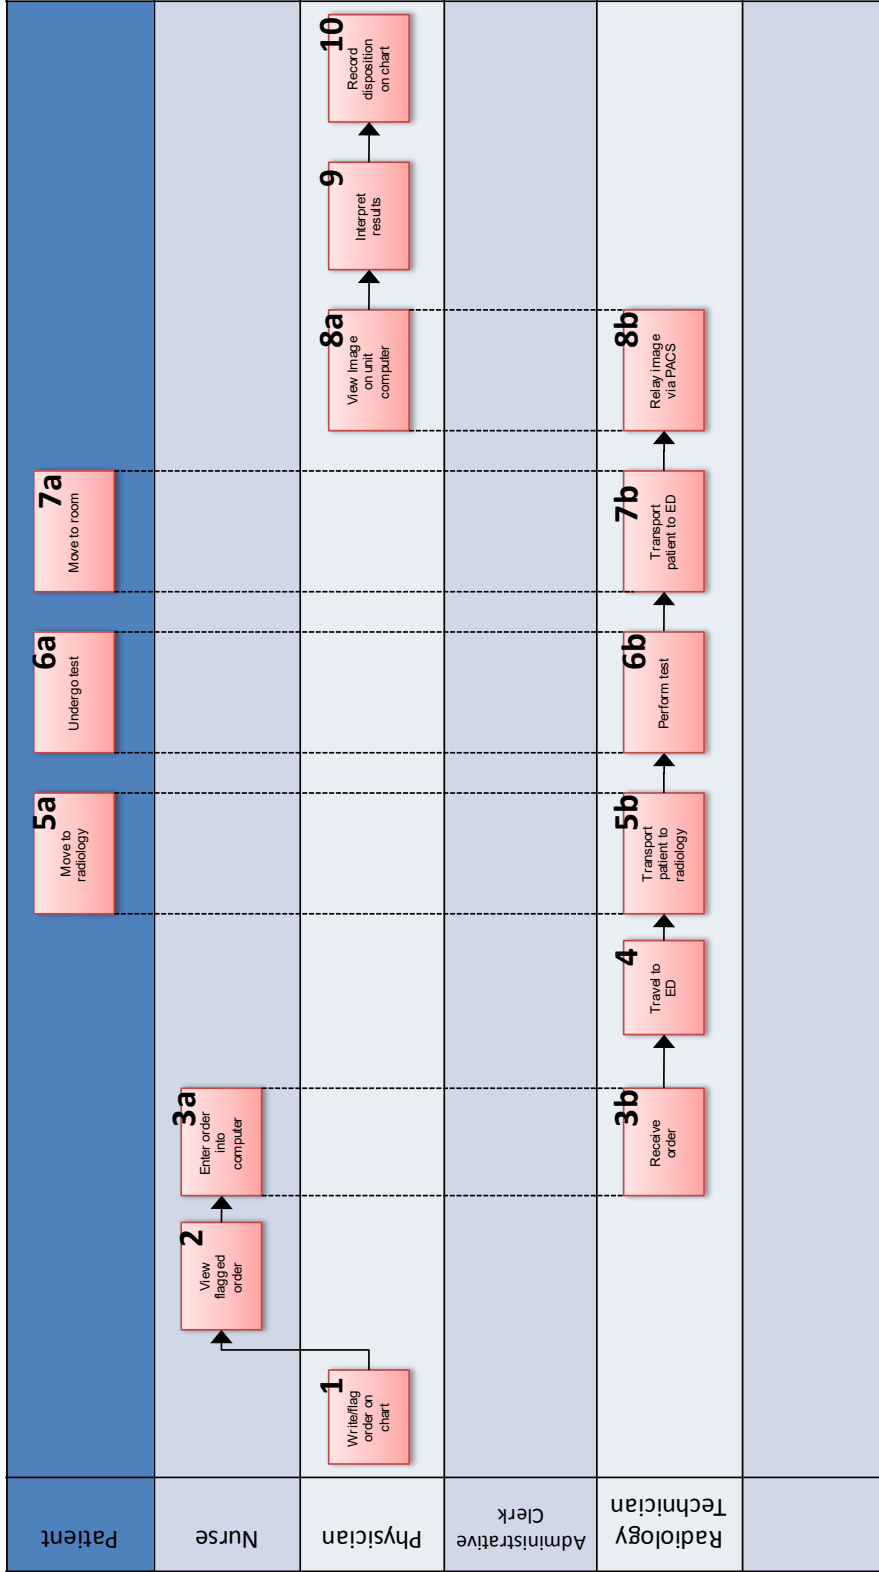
ED X-ray Imaging Process Map
